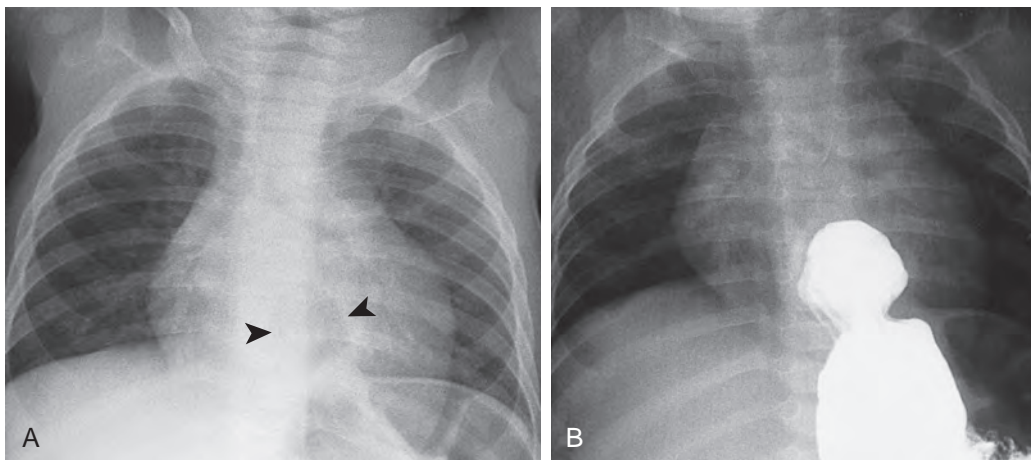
Failed Nissen fundoplication. A. A rounded retrocardiac air collection (arrowheads) on the chest radiograph represents the herniated stomach. B. The abnormally located gastric fundus is filled with barium. The indentation indicates the remnants of the gastric wrap.
